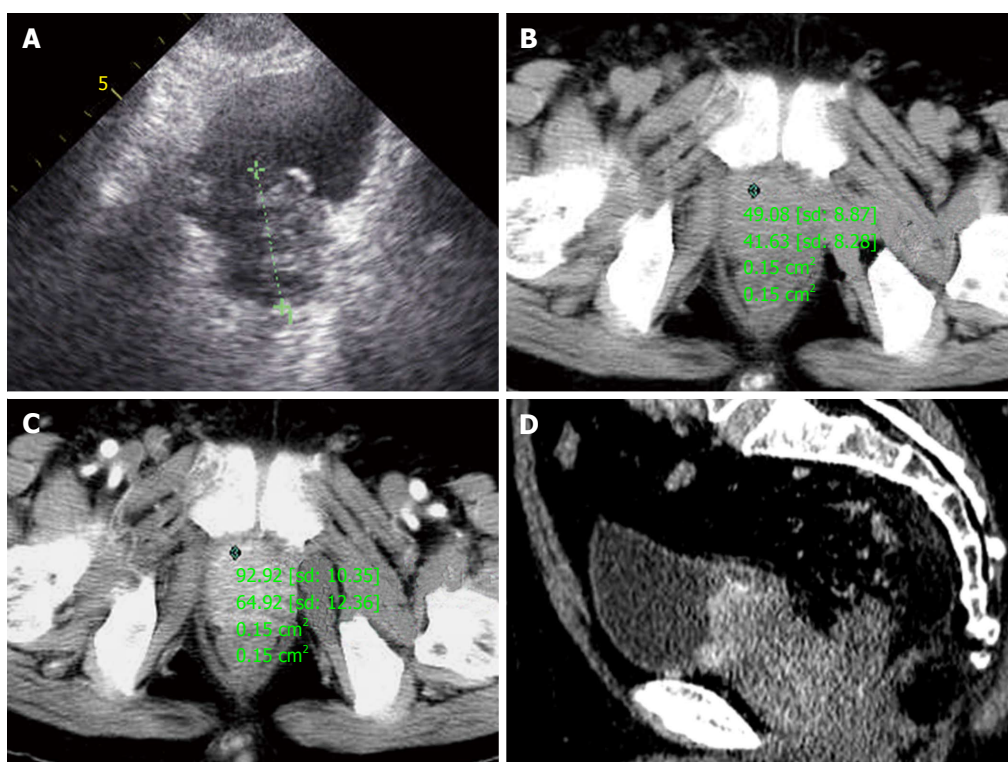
A 72-year-old male patient presented with one month of dysuria. A: Prostate enlarged to 4.0 cm \times 5.1 cm \times 4.2 cm with incomplete envelope, irregular shape and heterogeneous echo texture; B: A pre-enhanced computed tomography (CT) scan image of the pelvis showed a marked enlarged prostatic tumor invading to bladder, seminal vesicle; C: The enlarged prostate was inhomogeneous moderately enhancement in arterial phase; D: Coronal oblique multiplanar reconstruction of enhanced CT scan shows the enhanced inhomogeneous prostate with high attenuation protruding into bladder and unclear with surrounding tissue.
